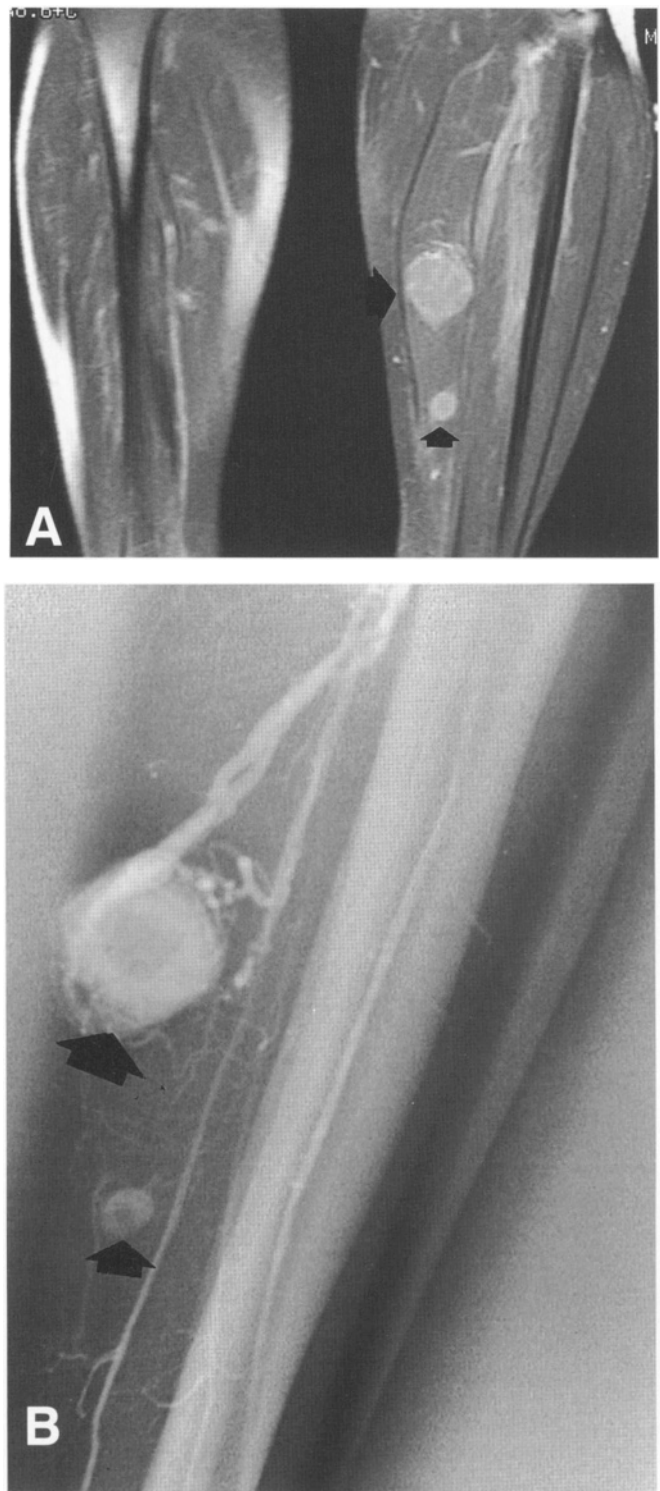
A 40-year-old woman presented with a rapidly enlarging mass that had developed in her calf. Physical examination revealed a deep-seated, firm mass, 10 cm in diameter, located at the proximal aspect of the calf. (A) Magnetic resonance imaging revealed the primary lesion and additional skip metastasis (small arrow) in the substance of the soleus muscle. Core needle biopsy of the primary lesion established the diagnosis of a high-grade leiomyosarcoma. (B) The skip metastasis (small arrow) is shown clearly in an angiogram performed before radical excision of the tumors. The large arrow represents the primary tumor
